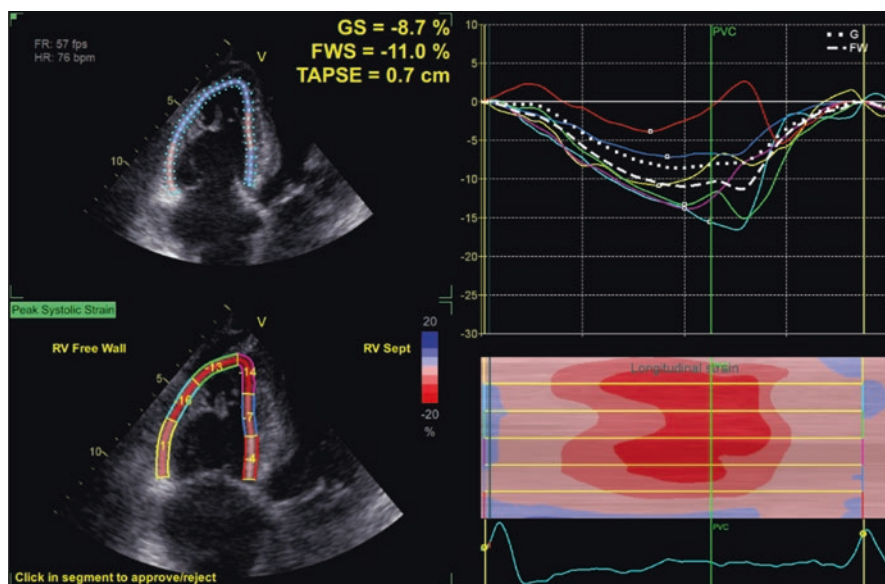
ATTR-wt Amyloidosis patient, transthoracic echocardiogram from an apical right ventricular (RV) focused view. RV longitudinal strain markedly reduced due to infiltrative disease. Global RV longitudinal strain = -8.7% , RV free wall strain = -11.0%
